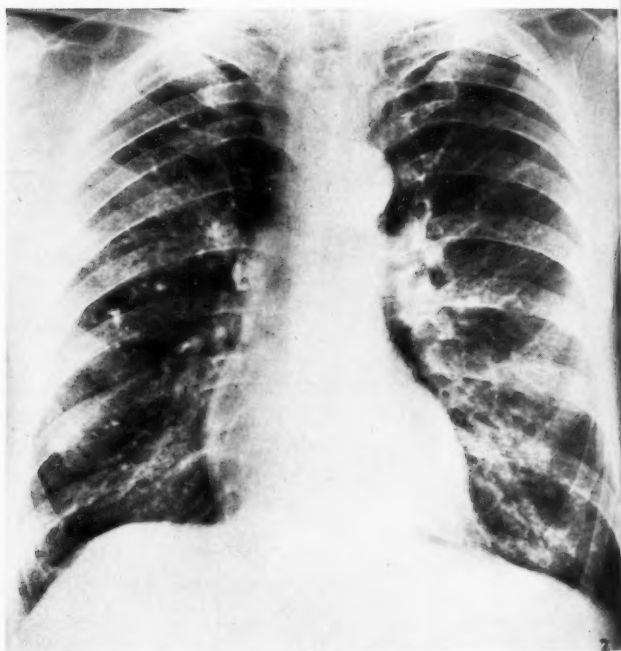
Case 2. Postero-anterior chest radiograph.
